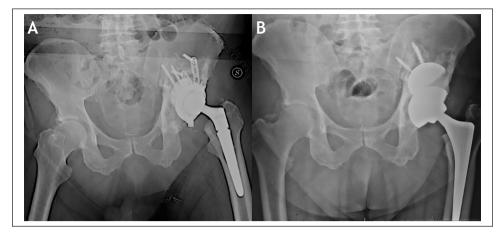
X- ray investigation in case of recurrent dislocation. A: preoperative x-ray with massive bone loss and proximal displacement of center of rotation. B: Postoperative I-year x-ray depicting optimal hip biomechanics recovery and no implant migration.
